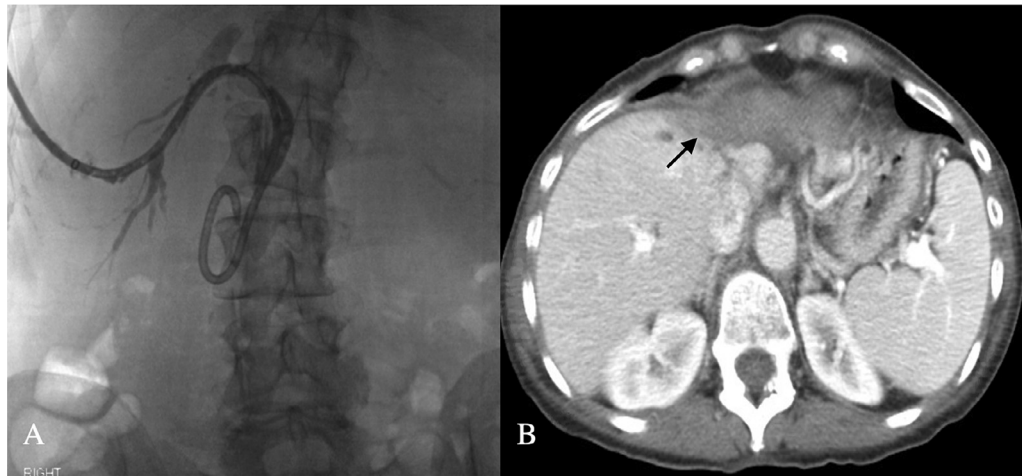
(A) Cholangiography through a 14 Fr internal/external biliary drain after 3 months shows complete resolution of biloma and no significant biliary ductal dilation. (B) CT abdomen after 3 month reveals atrophy of left hepatic lobe and hypotrophy (decompression) of right hepatic lobe.
